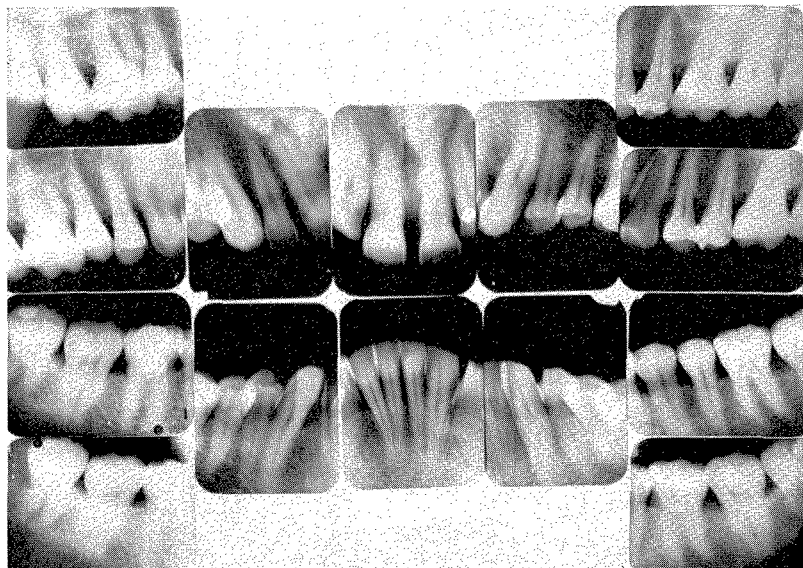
Roentgenograms taken in 1931, when the patient was 42 years old, showing a complete set of thirty-two teeth and good oral structures.
